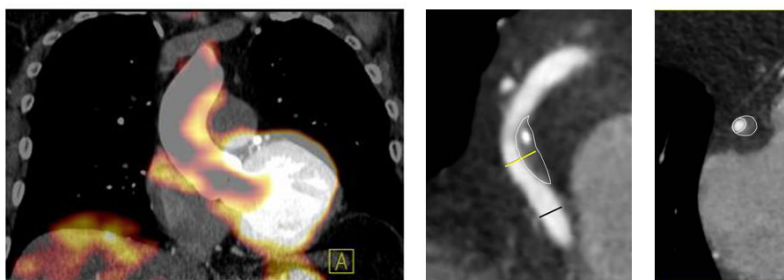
Panel A. Representative ¹⁸F-FDG-PET image from a subject with increased (2.36) aortic target to background ratio (TBR) demonstrated on coronal imaging. Panels B and C. Representative coronary computed tomography (CTA) long-axis (B) and short-axis (C) images in the same subject as Panel A, demonstrating a low attenuation, positively remodelled plaque with spotty calcification in the mid right coronary.
